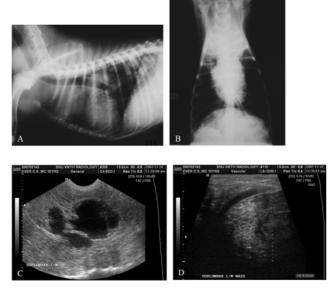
Lateral (A) and ventrodorsal (B) thoracic radiographs of case 1 showing multifocal pulmonary nodules, cranial mediastinal mass, cervical (prescapular) region mass, tracheobronchial and sternal lymphadenopathy. Ultrasonographic images (C, D) of case 1 showing extremely enlarged sublumbar lymph node with various cavitary lesions and irregular margination.
